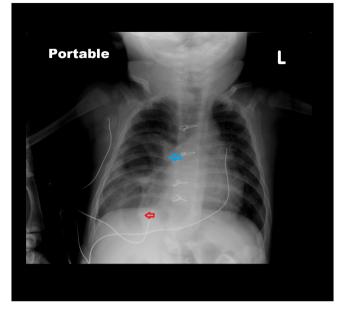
Chest radiograph performed three months after Norwood Stage 1 Operation showing bowel-like tubular lucency traversing the right hemi-diaphragm (red arrow) and right upper lobe lucency (blue arrow).
